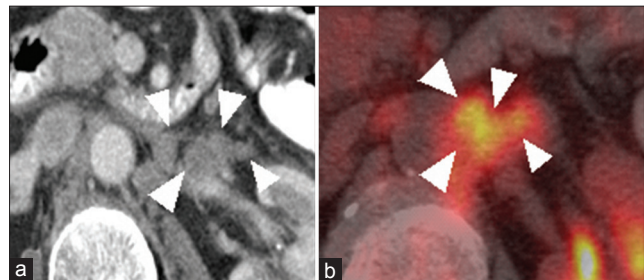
58-year-old male, with urothelial cancer, initially treated with radical cystoprostatectomy and adjuvant chemotherapy. Follow-up bone scan was suspicious for osseous metastases. a) Contrast enhanced-computed tomography (CT) and b) fused 18F-fluorodeoxyglucose (FDG) positron emission tomography/CT show clustering of enlarged FDG-avid lymph nodes in left para-aortic region, SULmax 6.9 (arrow heads).
